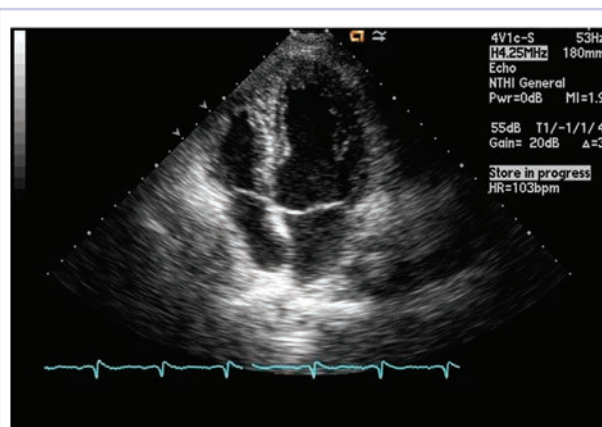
Follow-up echocardiogram showing resolution of tamponade.
